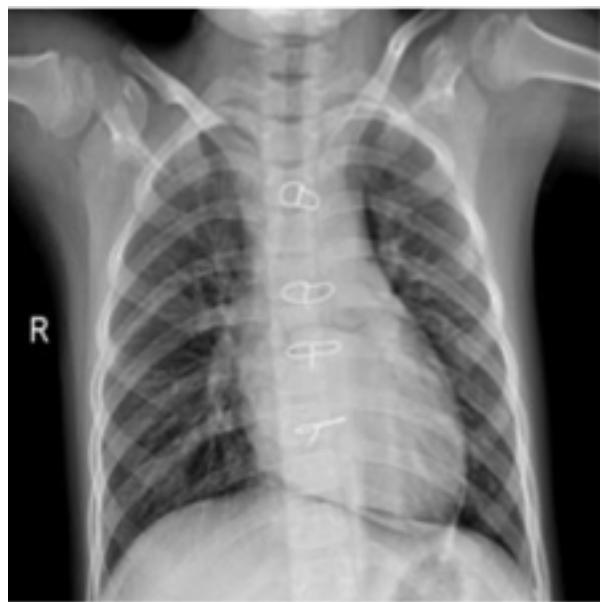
Radiograph of a lung diagnosed with viral pneumonia, not from COVID-19
